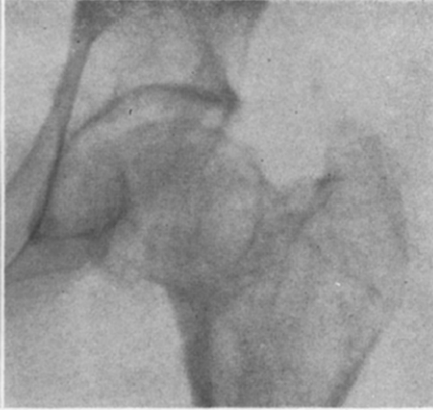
Case xix. Roentgenogram two years after drilling, February 24, 1939; firm union, well shaped head.
